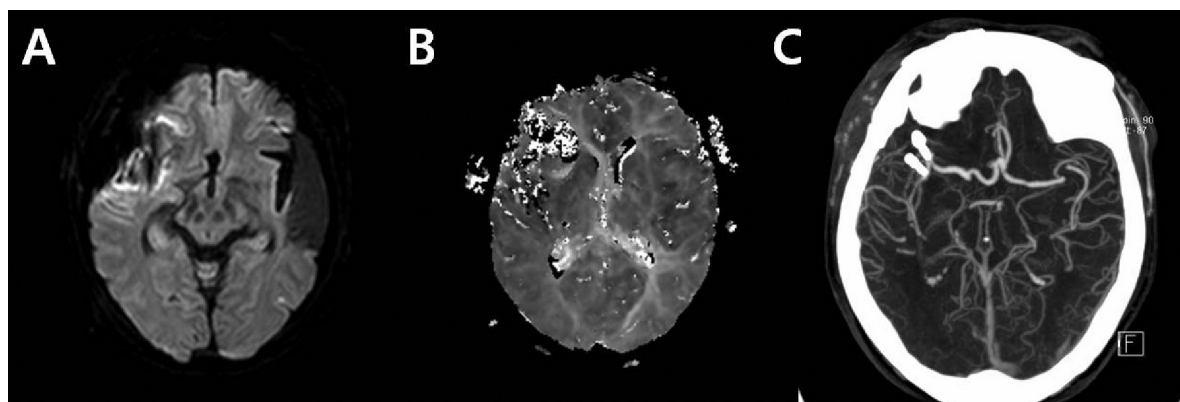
Diffusion-weighted image (DWI) (A) and perfusion-weighted image (PWI) (B) of the middle cerebral artery that was obtained 36 h after the operation revealed no diffusion restrictions or perfusion defects along the right middle cerebral artery (MCA) territory. (C) A postoperative computed tomography angiogram shows successful MCA recanalization with sufficient blood flow in the right MCA territory. Two mini-clips for closure of arteriotomy are noted.
